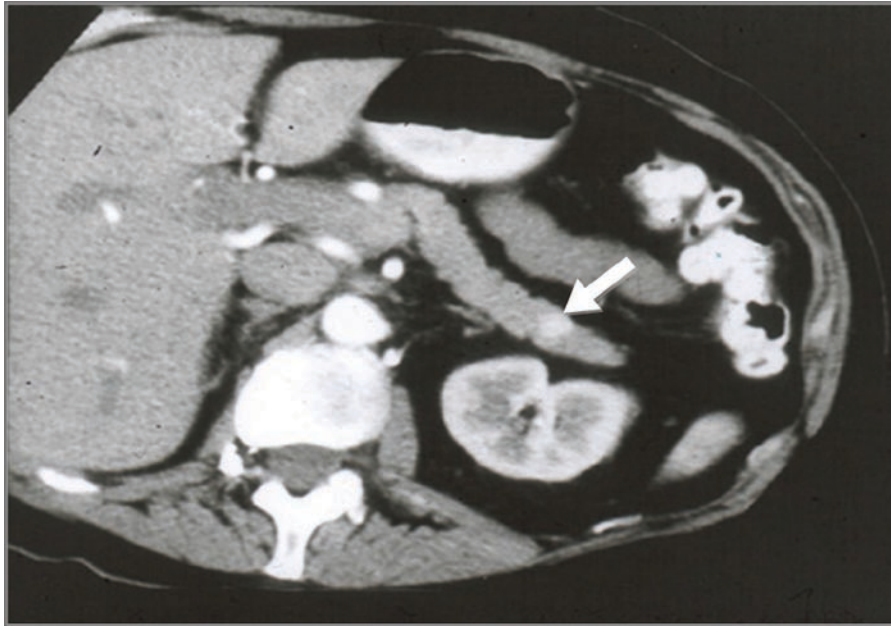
Spiral CT scan demonstrating an insulinoma in the pancreatic tail (courtesy of C.C. Reading, Rochester, Minnesota)
